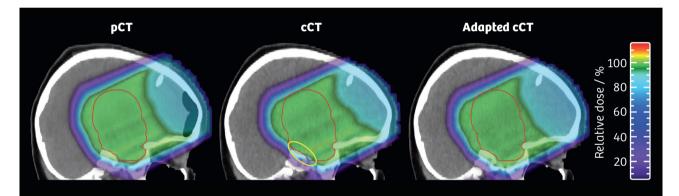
Anatomical changes during therapy. In this case of brain (glioblastoma) irradiation of a young child, a post-operative air-filled cavity was present at the time of the planning CT (pCT). In the control CT (cCT) at fraction 9 the cavity had disappeared, causing a severe under-range (yellow region). After adaptation of the treatment plan (right), the target volume was fully covered again. The CTV contour is represented by the red line.
